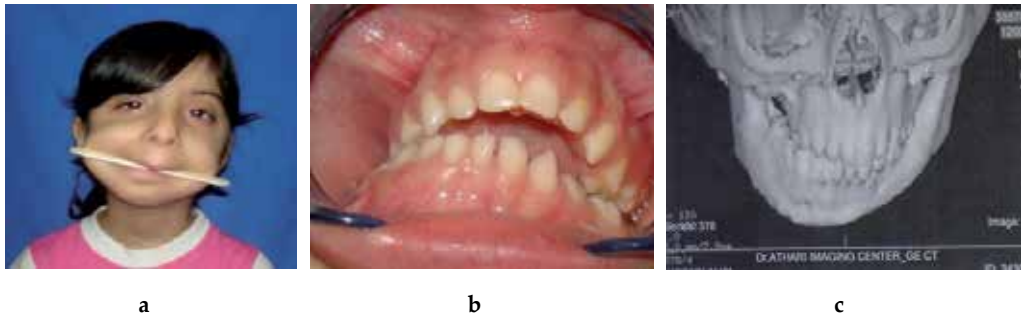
A 5-year-old girl with bilateral condylar ankylosis of unknown etiology (no history of trauma or infection). a) Extraoral facial photograph of the patient demonstrate the upper occlusal canting with the help of a tongue depressor, b) Intraoral photograph shows midline deviation, mandibular shift and increased overjet of the patient, c) three dimensional cone beam computer reconstruction of the patient demonstrates the facial asymmetry.
